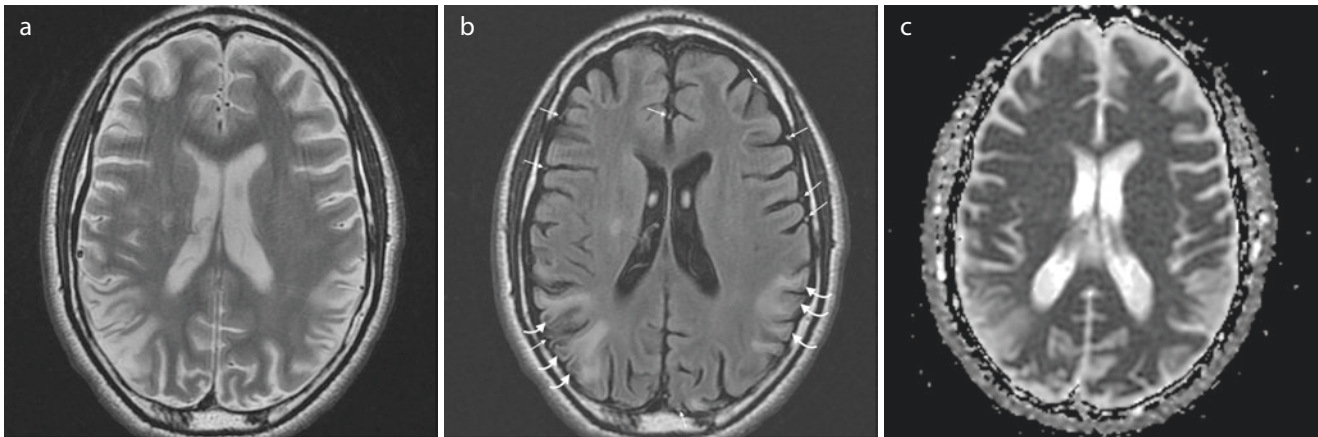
A 19-year-old male with MELAS. Axial T2WI (TR/TE msec, 3543/98) (a), T2 FLAIR (TR/TE/TI msec, 10,000/124/2200) (b), and apparent diffusion coefficient map (TR/TE msec, 10,000/95) (c) at the level of the lateral ventricles show bilateral parieto-occipital cortical/subcortical hyperintensity not confined to large arterial territories
